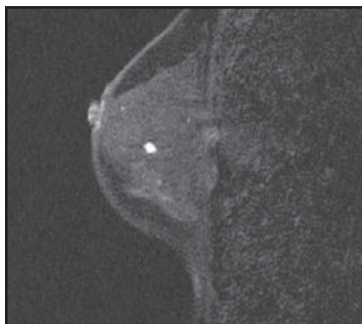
Images are taken without and then with intravenous contrast. The exam takes approximately 20 to 30 minutes. Breast MRI is available at The Fairfax MRI Center* which has state-of-the-art scanners, breast imaging coils, and highly trained radiologists dedicated to breast imaging and interpretation.
